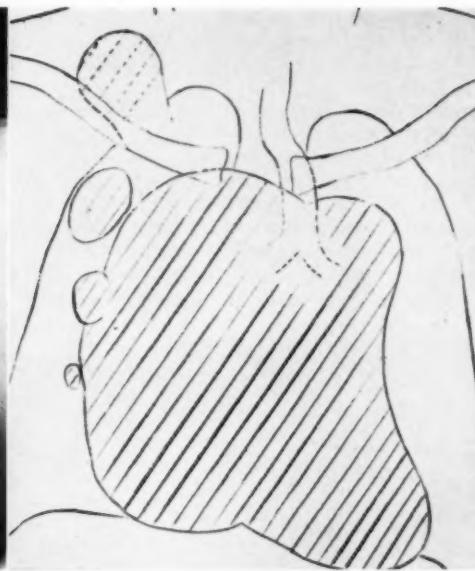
Roentgenogram of chest taken May 18, 1932, showing the saccular aneurysm with compression of the right upper lobe. There is also a pneumonitis in the left lower lobe.
